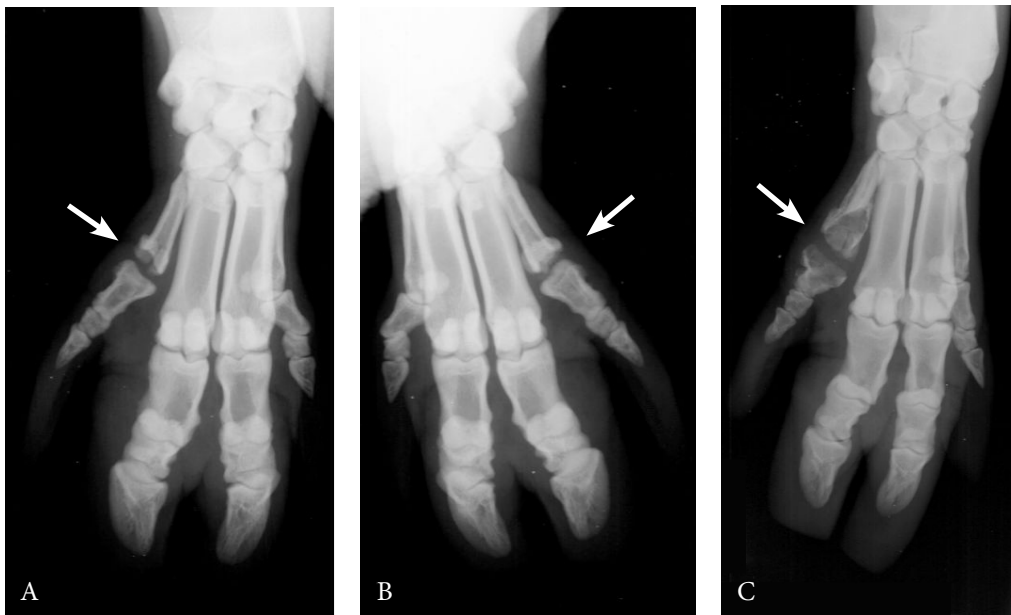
Radiograph at one year follow-up showing A) P(L/D)LA 96/4 joint scaffold, B) Swanson silicone implant, and C) P(L/D)LA 96/4 joint scaffold with a Polyactive® 1000PEO70PBT30 stem in the fifth MCP joint of the fore limb of a minipig (arrows)
